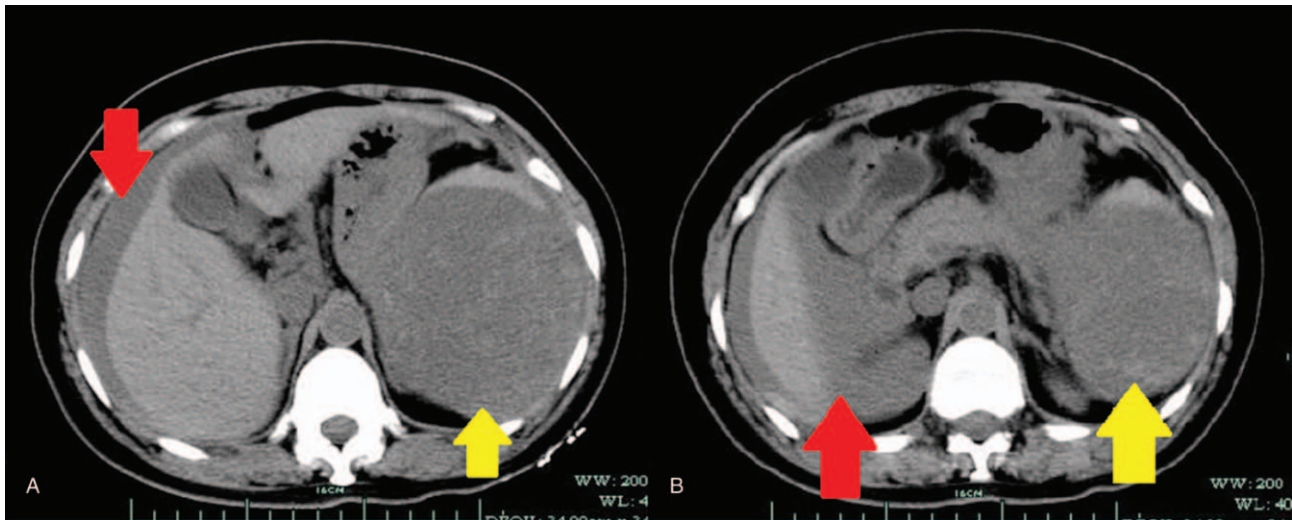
CT images of the splenic hemangioma with spontaneous rupture. CT scan demonstrating splenic mass (yellow arrow) with rupture hemorrhage and hydrops around liver (red arrow). CT=computed tomography.
